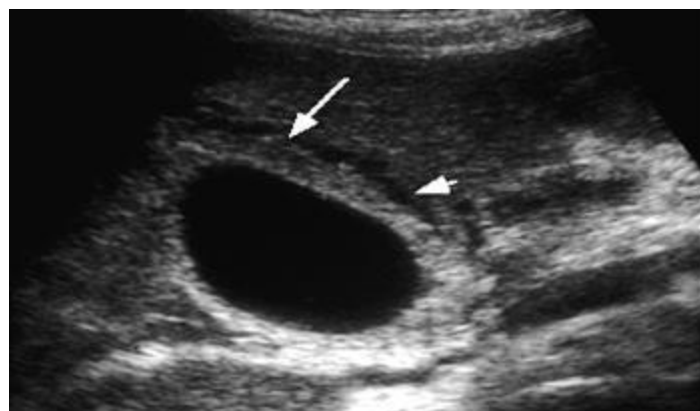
ultrasound image shows gallstones plus a thickened GB wall
